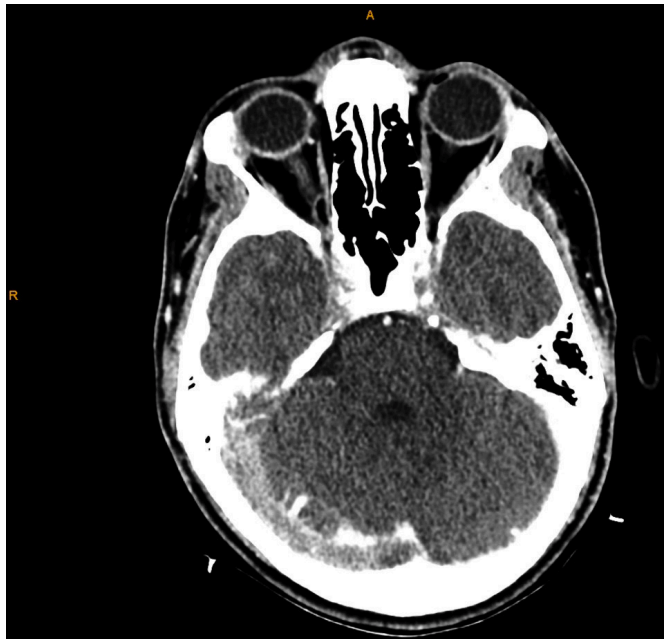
CT venogram showing significant under filling of the right transverse sinus with a filling defect, strongly suspicious of thrombus.
